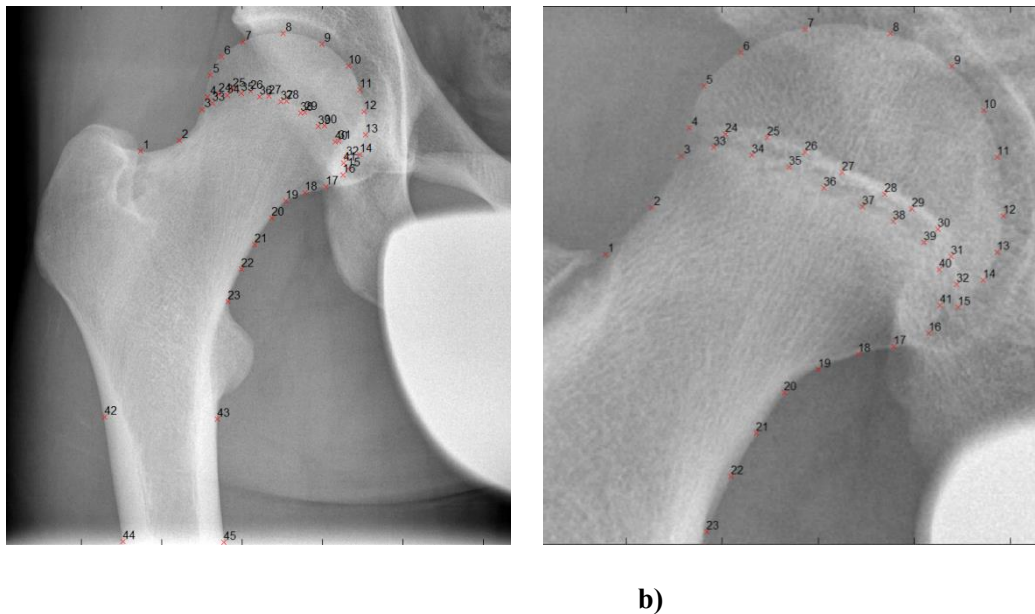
Positioning of the 45 landmarks on the radiographs using Matlab (a) and a close up to visualize the landmarks indicating the growth plate (b). The morphological measurements on Figure 4 are based on these coordinates.
